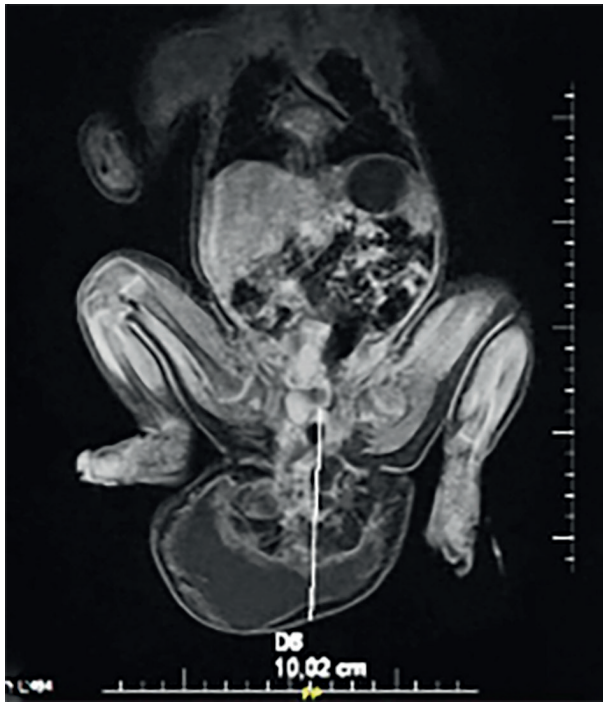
Magnetic resonance imaging of the abdomen and pelvis, lumbosacral teratoma
